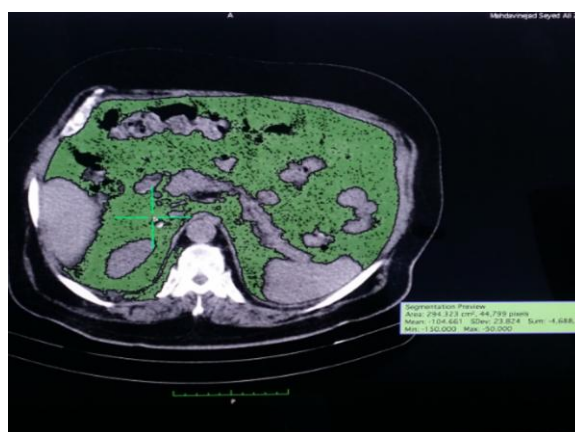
The CT scan of the patient showing the highest amount of visceral fat.
